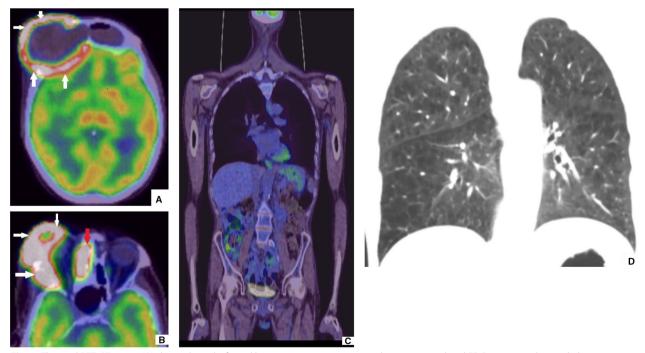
The axial PET-CT image (A) shows the right frontal bone tumour component with intense peripheral FDG activity and central photopenia. The axial PET-CT image (B) shows avid tumour within right upper nasal cavity (small red arrow) and large solid avid tumour within destroyed right frontal sinus (white arrows). There was no focus of avid uptake on PET imaging in thorax, abdomen or pelvis on coronal PET-CT (C). The lung window coronal image of CT thorax shows severe centriacinar emphysematous changes (D)
